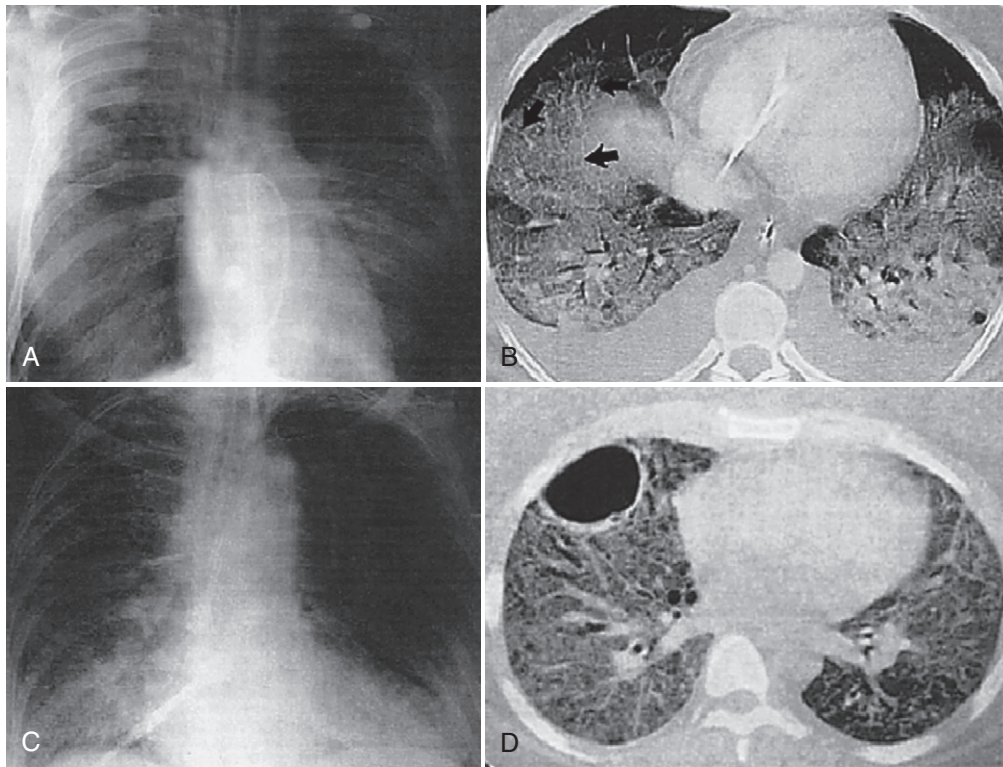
Radiograph and computed tomographic (CT) findings in the acute exudative phase (Panels A and C) and the fibrosing-alveolitis phase (Panels B and D) of acute lung injury and the acute respiratory distress syndrome. The arrow indicates thickened interlobular septa, consistent with pulmonary edema. (From Goodman LR: *Radiol Clin North Am* 34:33-46, 1996.)
